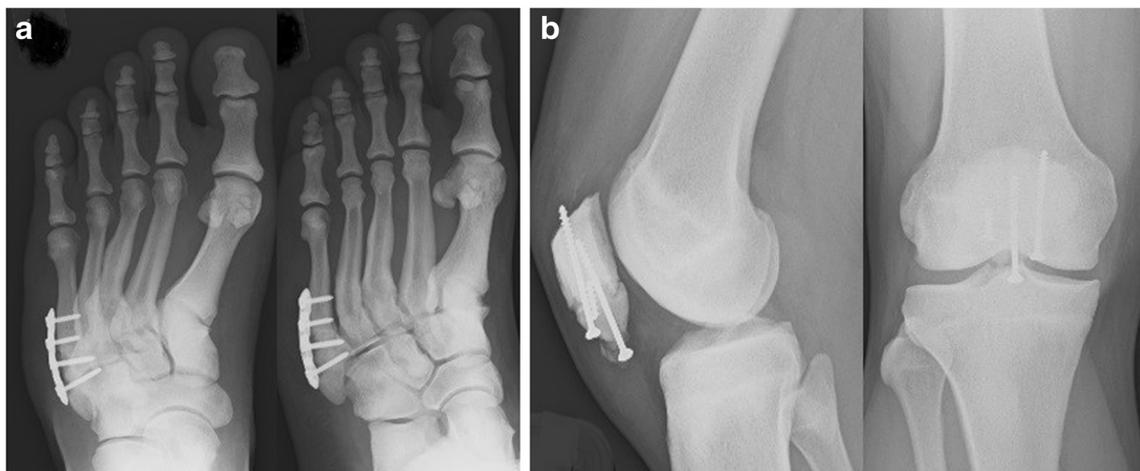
(Case no. 3) a Post-operative radiograph foot-AP and oblique after fixation of fifth metatarsal base fracture. b Post-operative radiograph of knee-AP and lateral after surgical fixation of the patella. Note one broken screw and one partially inserted screw
